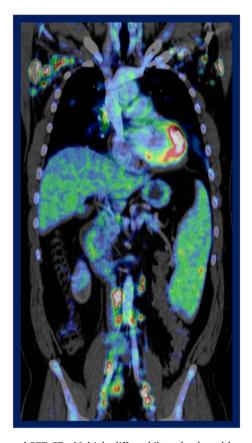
Coronal PET CT - Multiple diffuse, bilateral enlarged hypermetabolic lymph nodes are seen within the axilla, mediastinum, abdomen, and pelvis. Mild uptake is seen throughout the enlarged spleen.
